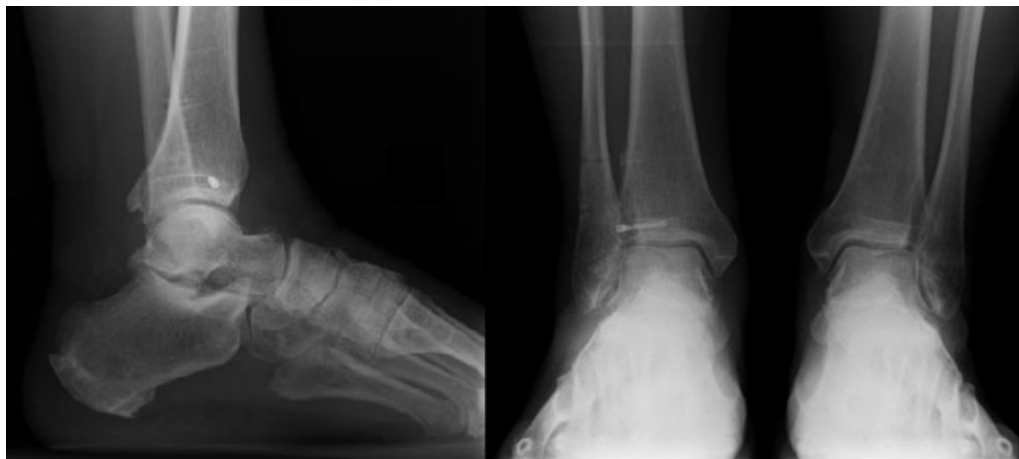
Weight bearing radiograph at 6 months follow-up.
